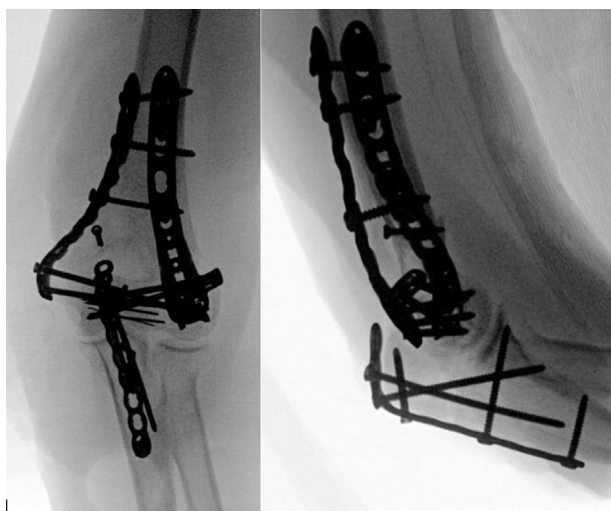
AP and lateral radiographs demonstrating the authors preferred olecranon osteotomy fixation using a self-contoured 2.7 mm minifragment plate and screw construct. AP, anterior-posterior.
